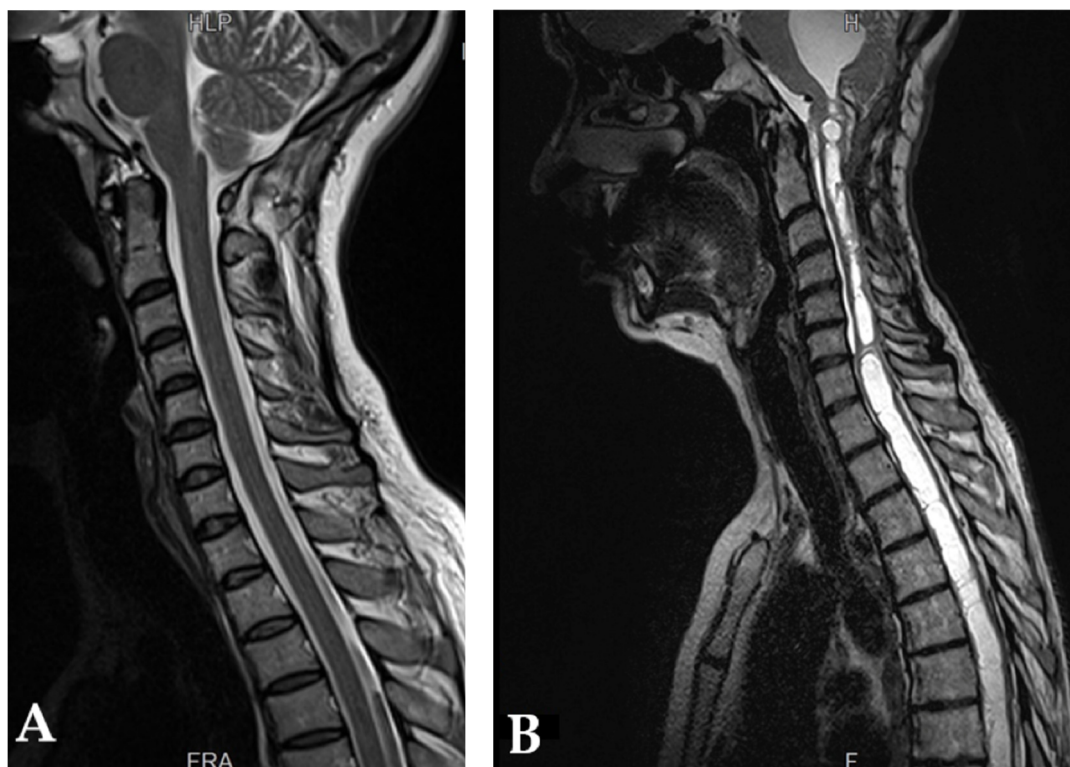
MRI in sagittal T2-weighted sequence (A) and T1-Gadolinium sequence (B) are shown. Cerebellar tonsillar ectopia is revealed and a significant syrinx cavities filled with cerebrospinal fluid is depicted (Personal case of Assoc. Prof. Horia Ples MD, PhD.).
